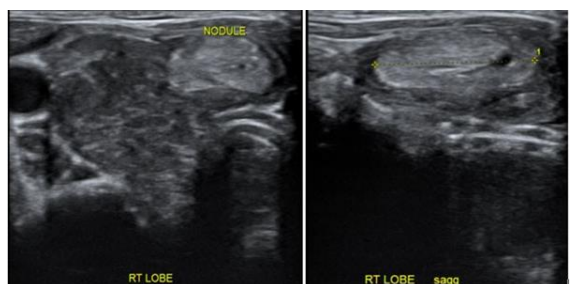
Axial and longitudinal ultrasound images of the thyroid shows a solitary nodule in the right lobe. Based on TIRADS, the nodule is almost completely solid (2), hyperechoic (1), wider than taller (0), has smooth margin (0) and no echogenic foci (0). TIRADS Category: 3
